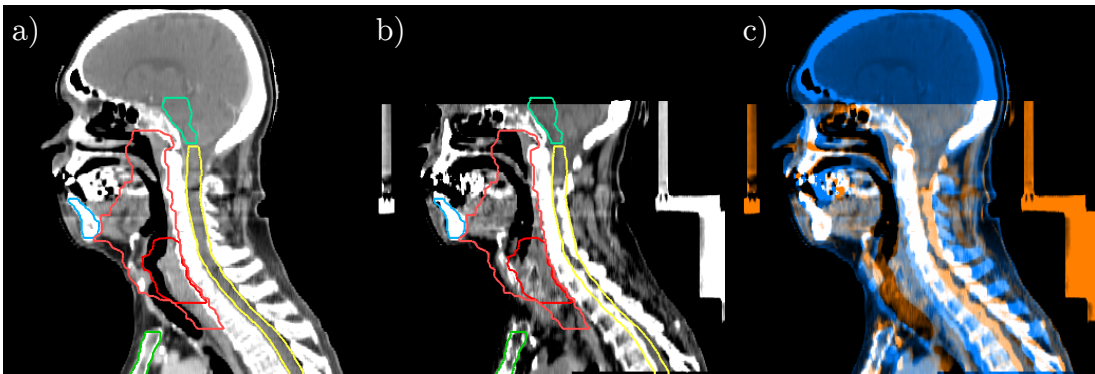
Representative image data indicating inter-fractional motion. a) Planning CT including target volumes (red) and OAR contours. The spinal cord contour (yellow) is correctly delineated b) Fraction CT with original contour overlay of planning CT. The spinal cord contour (yellow) does not match the actual spinal cord position in the image anymore. c) Image fusion of planning CT (blue) and fraction CT (orange) shows the movement in the image space (alignment would show in gray scale, see Section 2.2.1).
